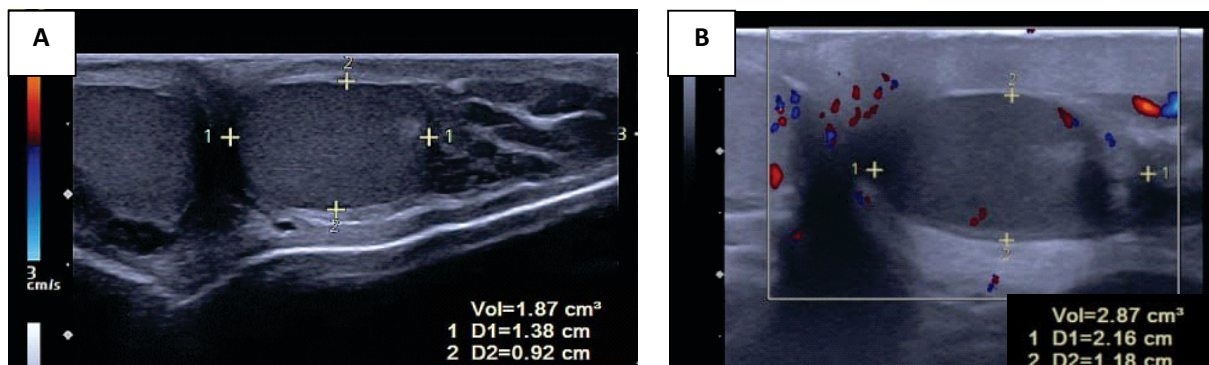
Left testicular ultrasound (A) Before surgery, testicular volume was 1.87 cc; (B) 2 months After surgery, testicular volume increased to 2.87 cc.
